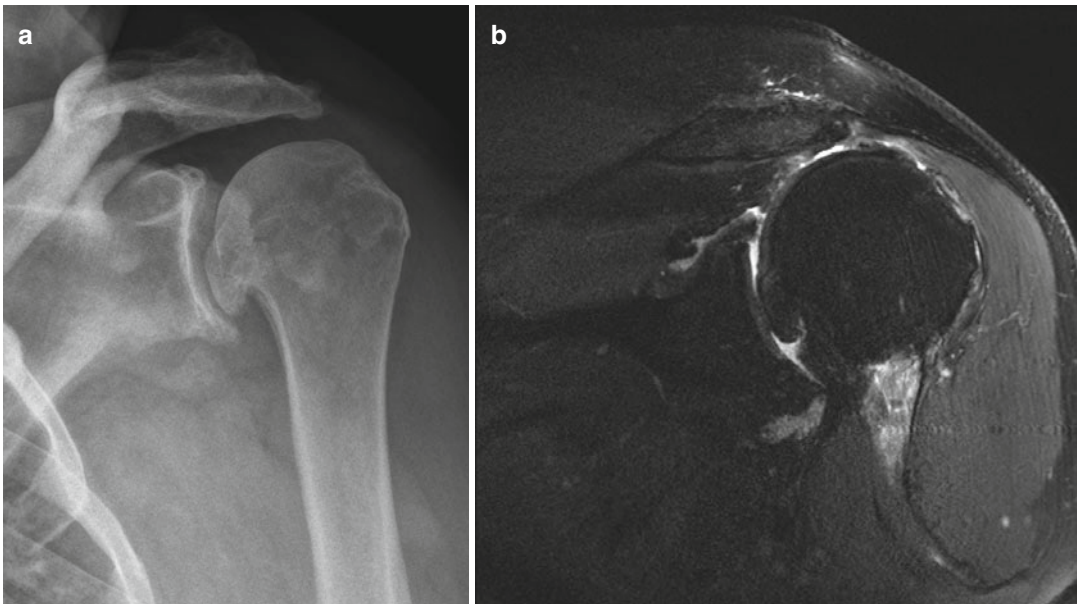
(a) Grashey view of shoulder with osteoarthritis and significant rotator cuff weakness. (b) Coronal MRI cut showing massive retracted supraspinatus tear with cartilage loss
